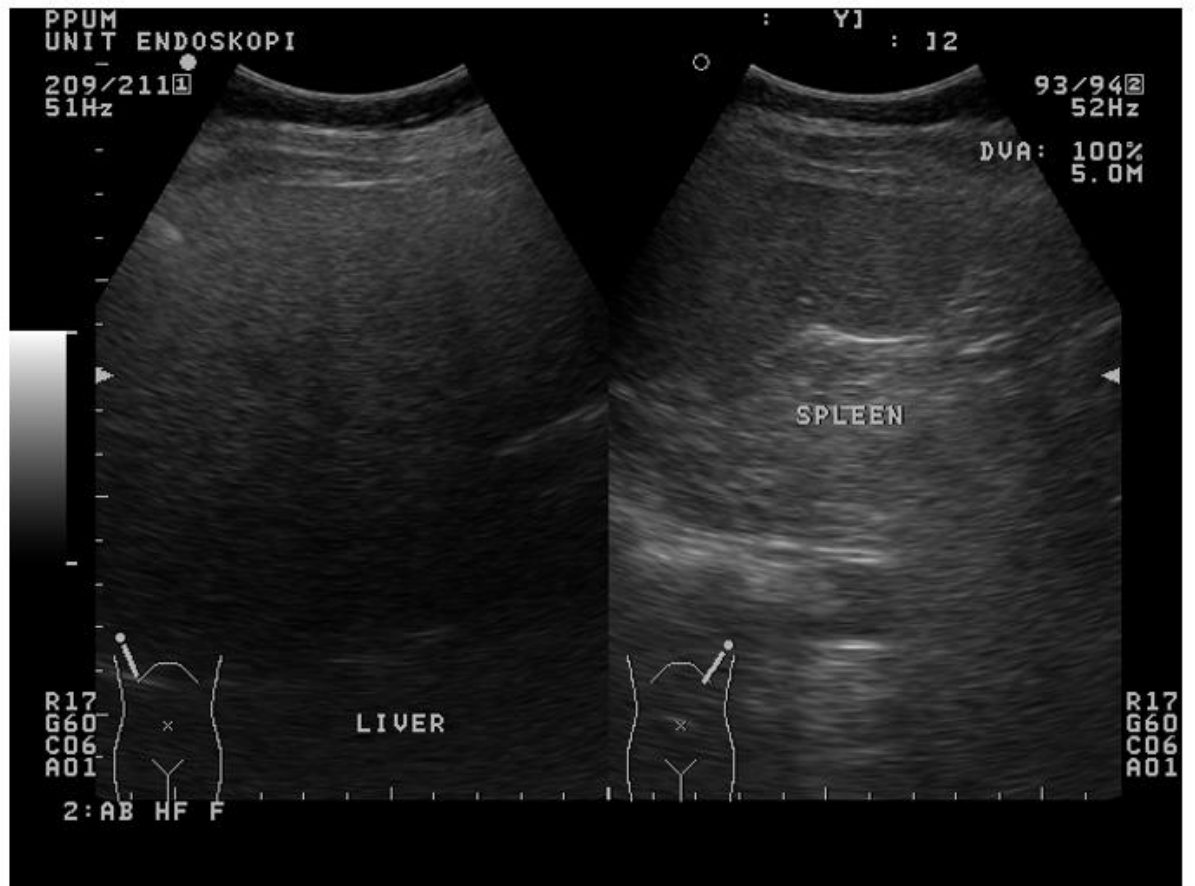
Fatty liver on ultrasonography
